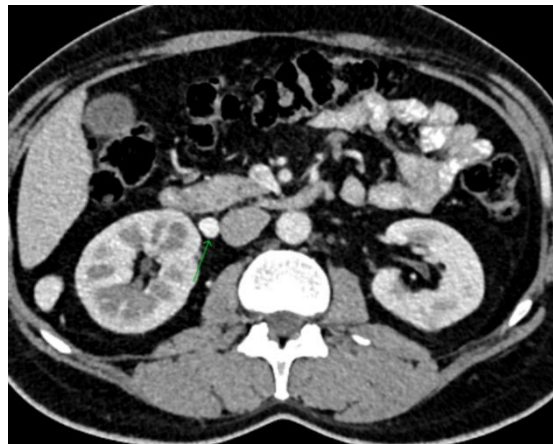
Magnified axial CT (green arrow) demonstrating a prominent cortical draining vein
